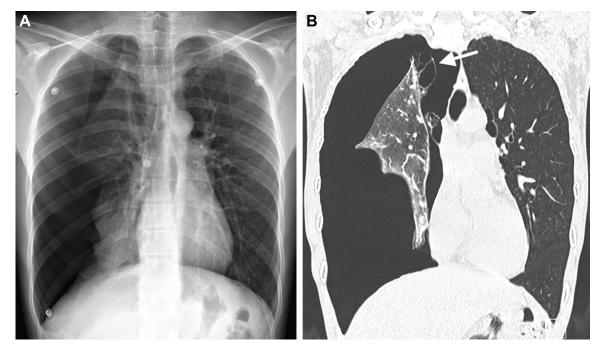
A, Posterior-anterior chest radiograph in 34-y-old man with acute right chest pain and history of daily marijuana use, demonstrating a large right pneumothorax. B, Coronal CT image in the same patient demonstrating a large right pneumothorax and relatively advanced premature paraseptal emphysema and bullous changes (arrow).
